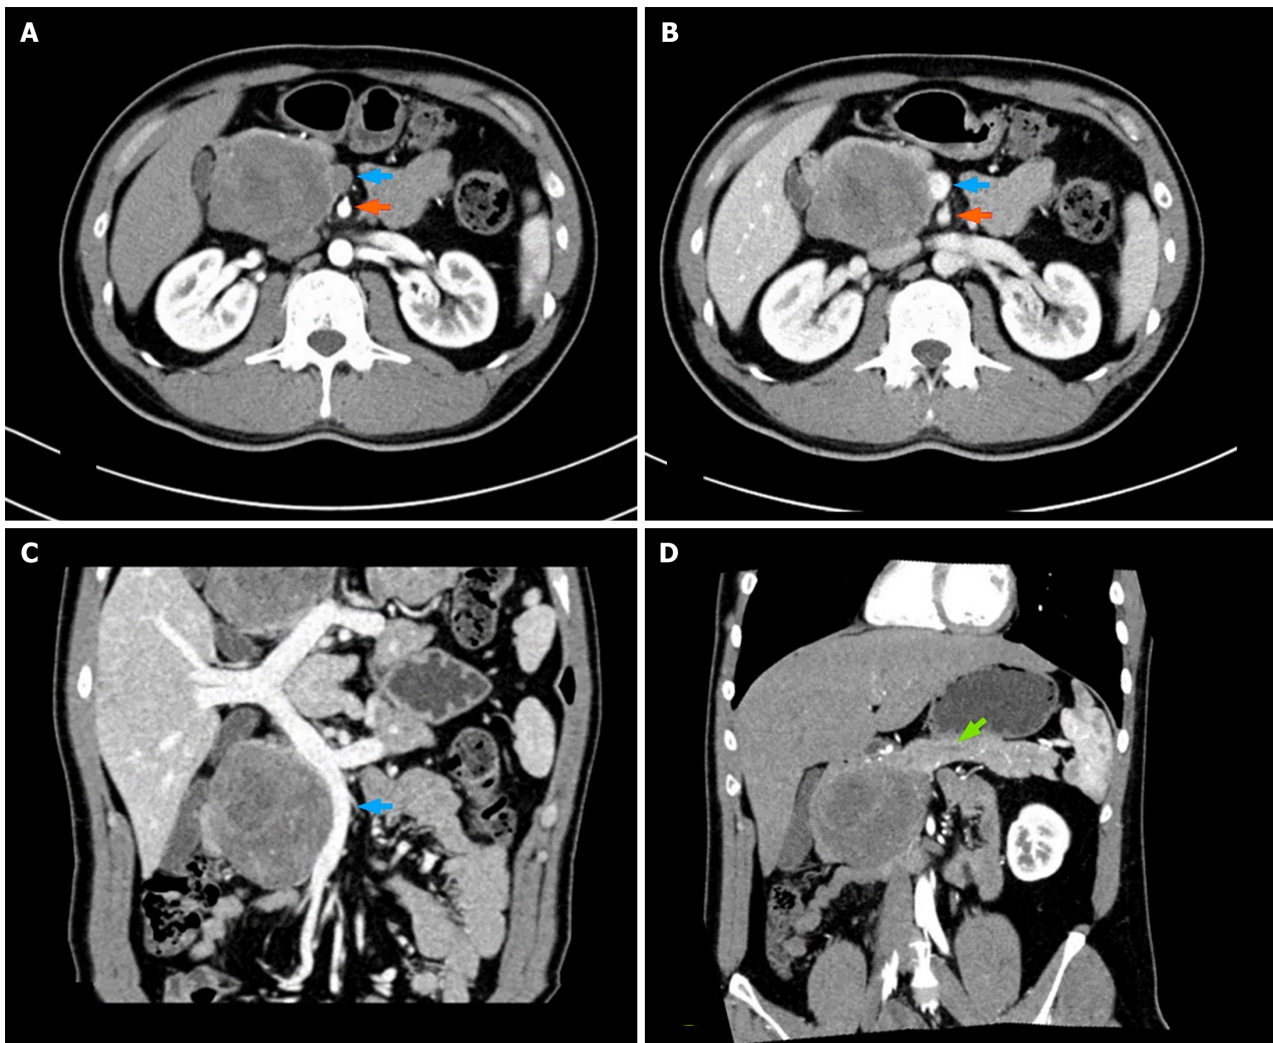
An enhanced computed tomography image of the abdomen revealed a mass in the head of the pancreas. A: Arterial phase; B: Portal phase; C: Portal venous system reconstruction; D: Coronal reconstruction. Blue arrow: Superior mesenteric vein; Orange arrow: Superior mesenteric artery; Green arrow: Main pancreatic duct.
